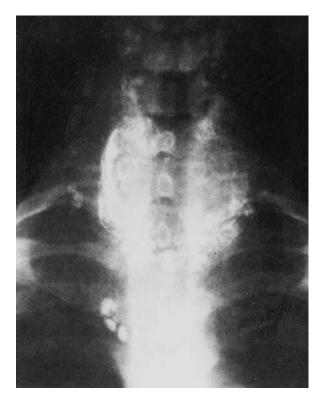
Radiograph of the neck and upper chest of a patient following injection of iodized oil (Lipiodol) into the thyroid gland. Note the flow of contrast laterally and downward along lymphatic channels. Courtesy of O. H. Clark, MD, Department of Surgery, University of California-San Francisco/Mount Zion Medical Center, San Francisco, CA.
